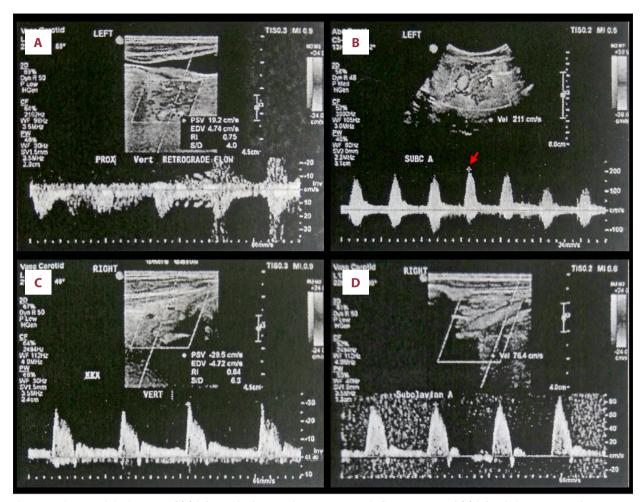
Ultrasound duplex scan of (A) left vertebral artery showing retrograde flow pattern and (B) left subclavian artery showing increased flow velocity of 211 cm/s (arrow) suggesting subclavian artery steal syndrome. (C) Right vertebral artery showed slightly reduced flow velocity and late-systolic deceleration which might be a sign of mild subclavian steal phenomenon and (D) right subclavian artery showed normal triphasic waveform.
